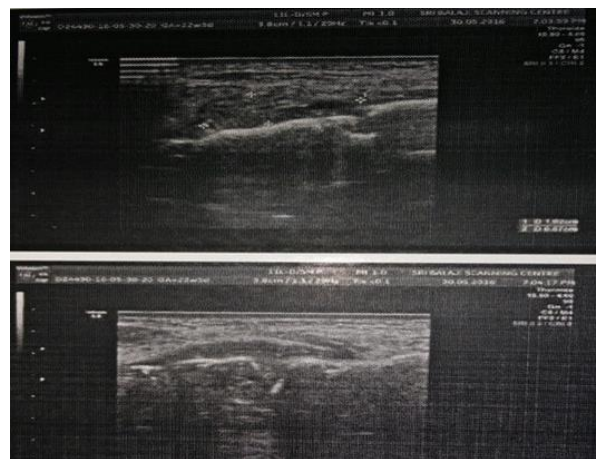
ultrasound images showing ill-defined edges, heterogeneous pattern, hypoechoic intensity no collection and only increase in thickness of subcutaneous tissue and muscle involved, then the diagnosis was made as cellulitis
